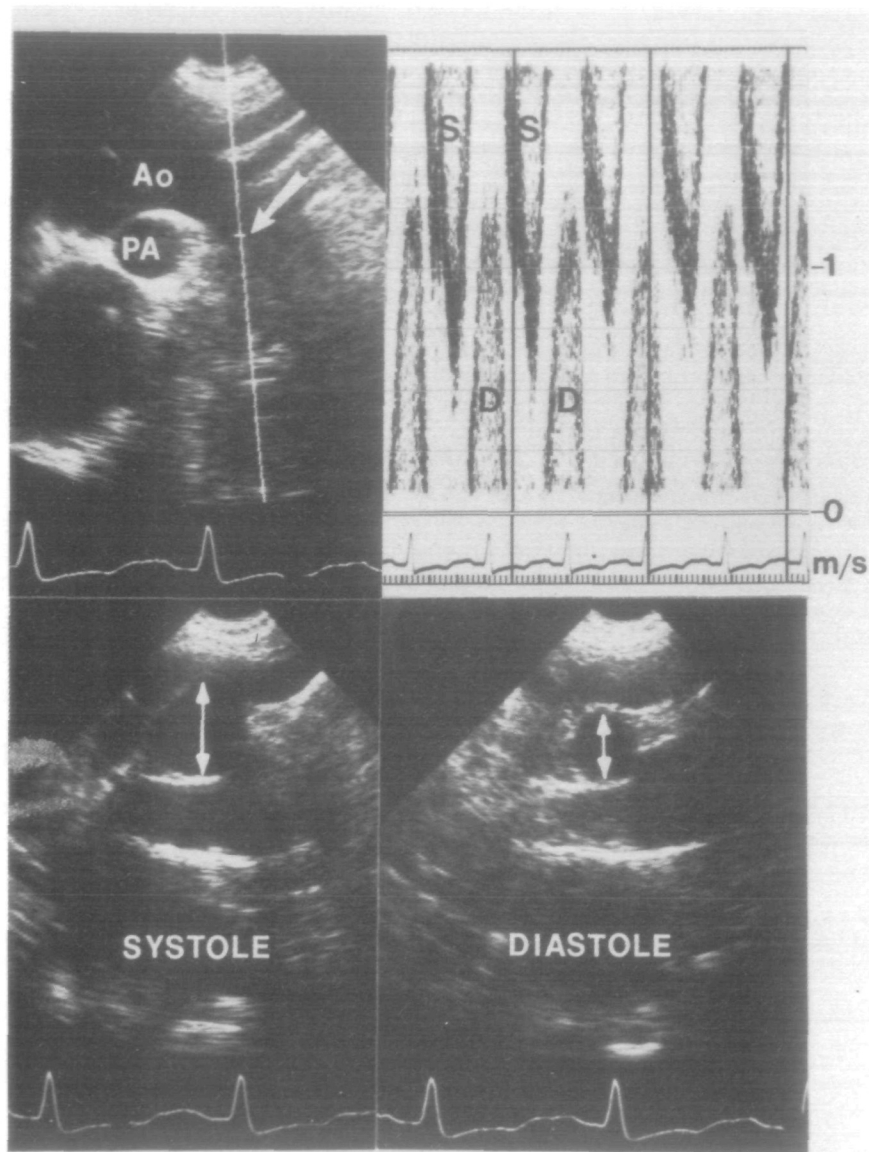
Measurement of forward and reverse flows in aortic regurgitation. Using a suprasternal approach (top left), flow in the proximal descending aorta (Ao) is recorded (arrow). The area under both systolic (S) and diastolic (D) waveforms is planimetered (top right). Vessel cross-sectional area is determined from both systolic and diastolic diameters (bottom panels). Maximum systolic diameter is used to determine systolic cross-sectional area, while diastolic and systolic diameters are averaged to determine mean diastolic cross-sectional area. Regurgitant fraction is determined as the ratio of diastolic to systolic velocity integrals, multiplied by the ratio of diastolic to systolic vessel area. In this patient with severe AR, Doppler regurgitant fraction was 63%.
